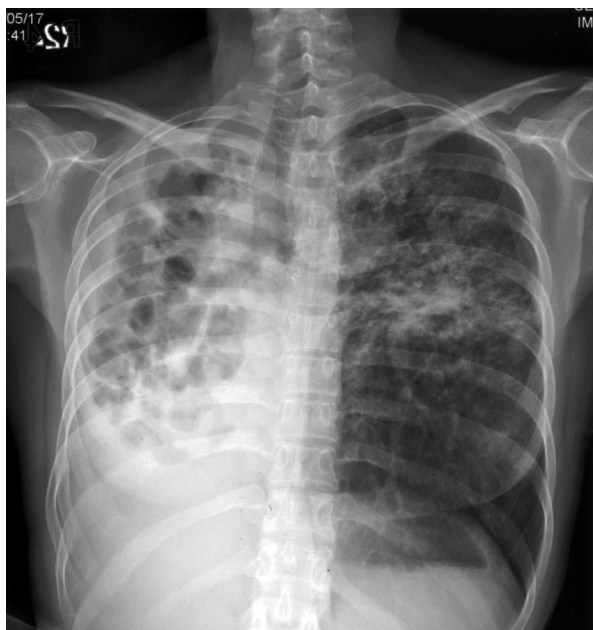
Chest radiograph showing a destroyed right lung with multiple cavities, and infiltrates at the left upper lung.
